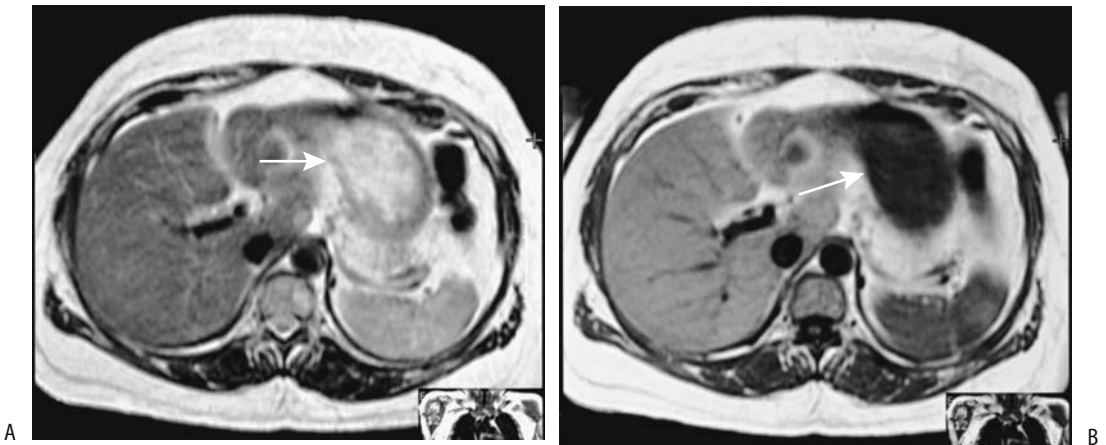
Hyalinized hemangioma. A T2-weighted fast spin echo (FSE) MRI (A) reveals a hyperintense (arrow), and a T1-weighted FSE MRI (B) reveals a hypointense (arrow) tumor. US (not shown) suggested a complex cyst. US-guided biopsy provided a diagnosis. (Courtesy of Patrick Fultz, M.D., University of Rochester.)
